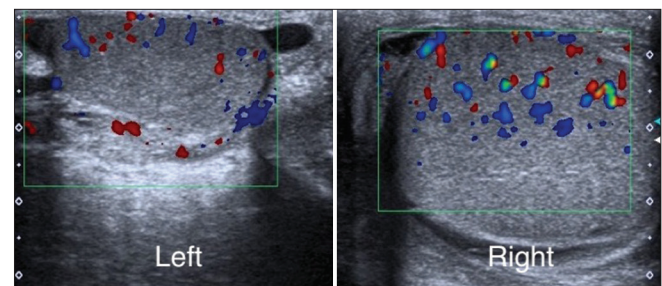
Color Doppler ultrasound in the longitudinal plane of both testicles
